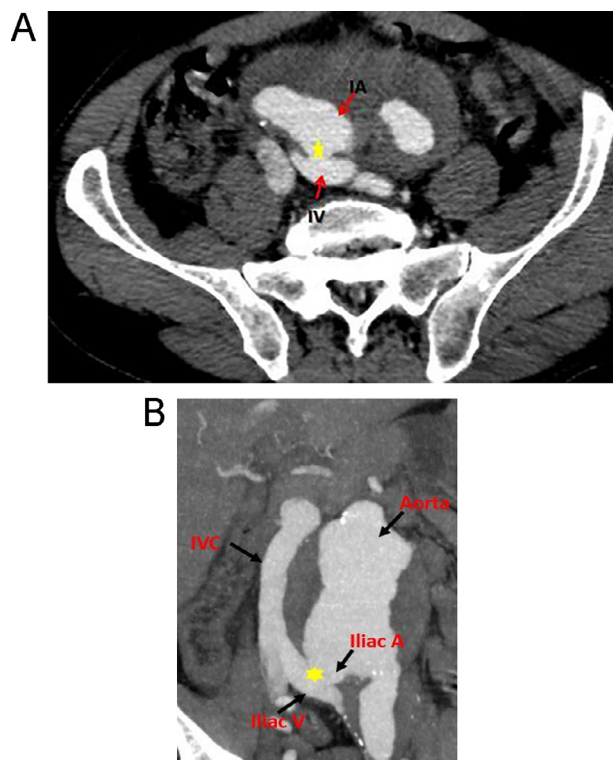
CT Angiographic images at arterial phase in axial section (A) and coronal MIP reconstruction (B) showing an aorto-biliac aneurysm with communication between the right common iliac artery and the left common iliac vein: arteriovenous fistula (yellow star). Note the retrograde enhancement of the IVC.
